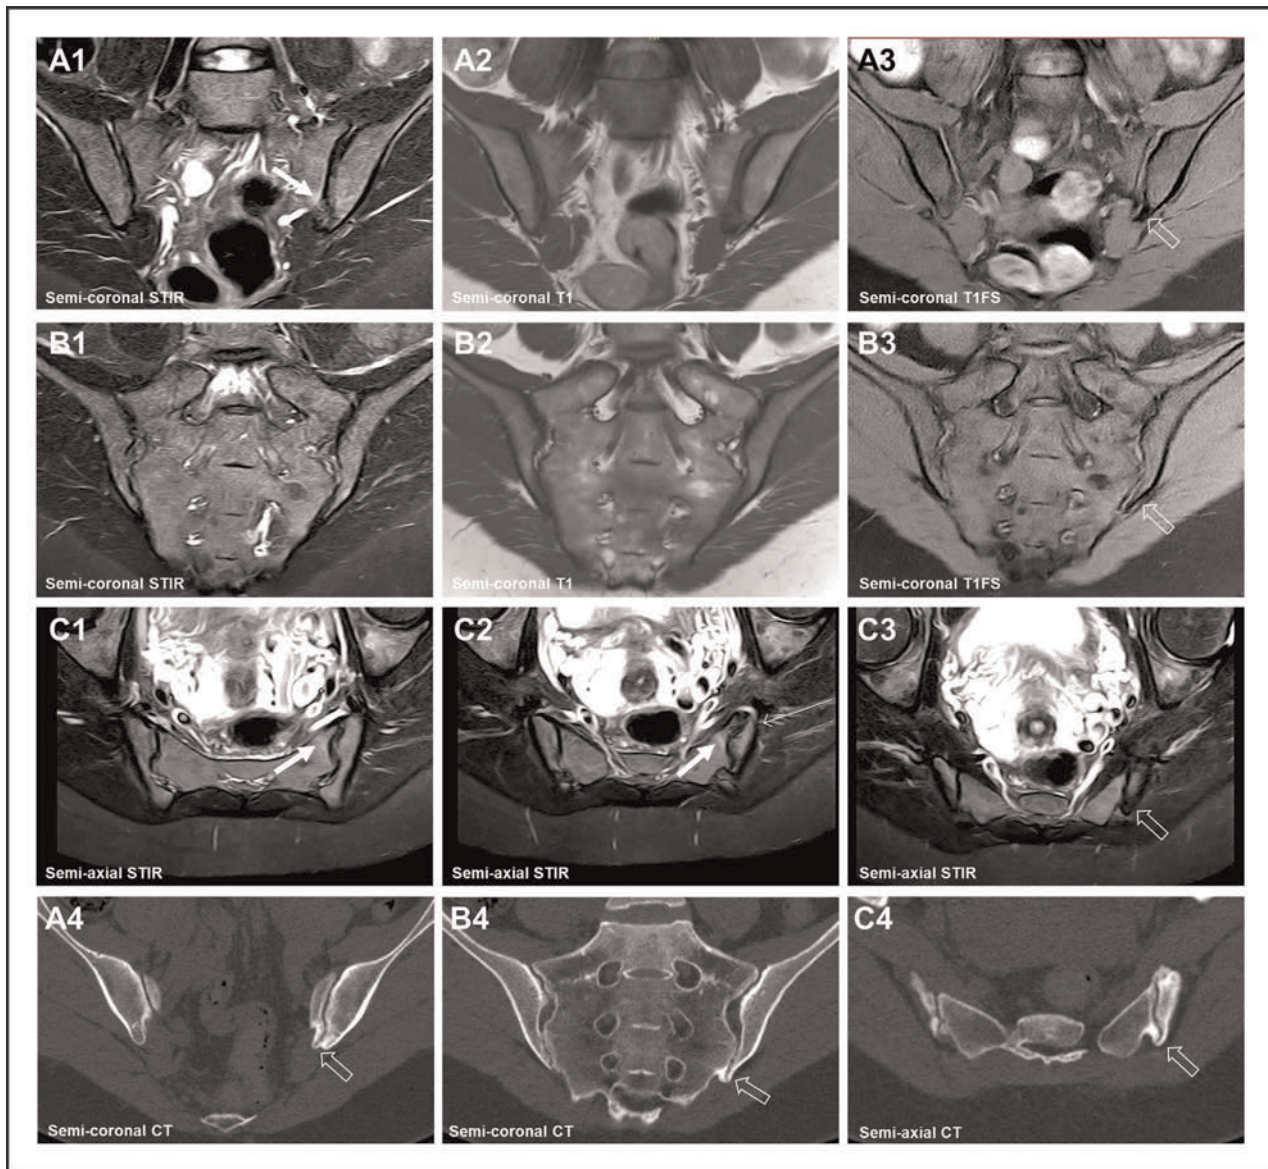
Degenerative changes. MRI in a 35-year-old woman with low back pain, but no clinical or biochemical axial spondyloarthritis suspect changes. Semi-coronal STIR and corresponding T1-weighted and T1FS images anteriorly (a1, a2, a3) and posteriorly (b1, b2, b3) in the joints with concomitant semi-axial STIR images at the middle (c1) and lower part of the joints (c2, c3), and CT images in the same slice orientations (a4 corresponding to a1–a3, b4 to b1–b3 and c4 to c3). There is slight subchondral BME anteriorly in the sacrum on the left side (arrows on a1, c1) and slightly irregular joint facets without erosion, but the T1FS images show osteophyte formation anteriorly and posterior/inferior at the left SIJ (open arrows on a3, b3). The manifest osteophyte formation seen on the CT images (open arrows on d2, d3) are very difficult to detect on T1 and STIR images, and on T1FS the osteophyte formation posterior/inferior is seen only as a signal void mass (open arrow on c3) and is more difficult to appreciate compared to the osteophytes that are obvious on CT. BME, bone marrow edema; SIJ, sacroiliac joint; STIR, Short Tau Inversion Recovery; T1FS, T1 fat suppressed.
